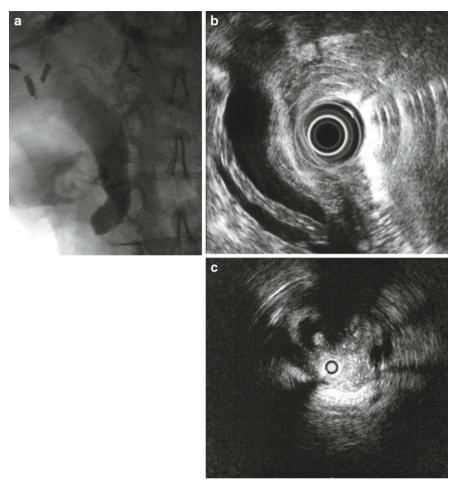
(a) Cholangiogram reveals abrupt termination of the bile duct with poor drainage of contrast. (b) At EUS, borderline dilation of the bile and pancreatic ducts are noted without the obvious presence of a tumor mass. (c) On intraductal ultrasound, a 1 cm endoampullary mass is noted as a papillary projection. At surgery, this patient was found to have a 1 cm ampullary cancer invading the distal CBD.
